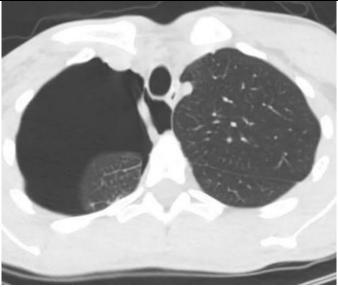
Chest computed tomography revealing large persistent pneumothorax after pleural drainage and azygous lobe.
